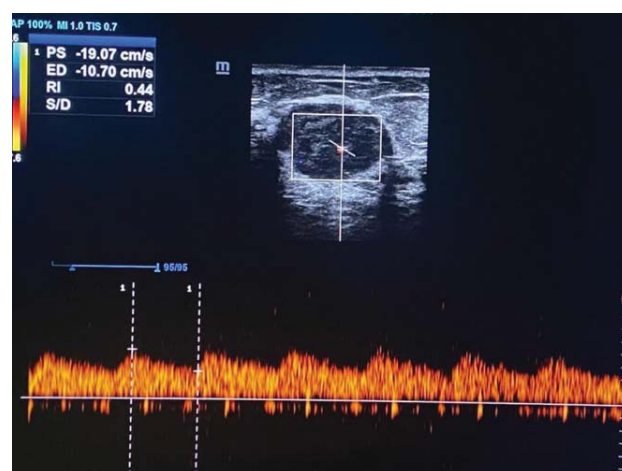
Doppler ultrasound of breast lesion showing RI value of 0.4 suggesting a malignant looking lesion.
